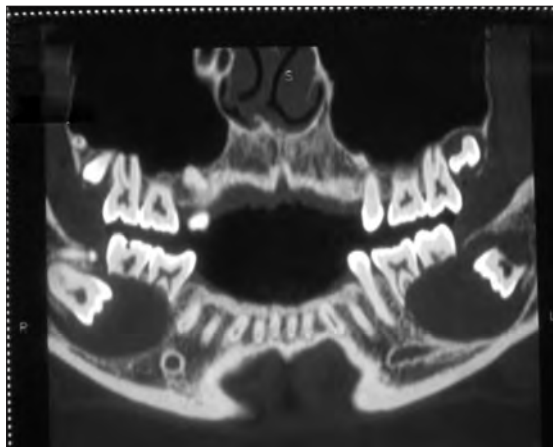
CT image showing bilateral expansile radiolucent lesion surrounding both the mandibular and maxillary third molar regions along with supernumerary teeth
